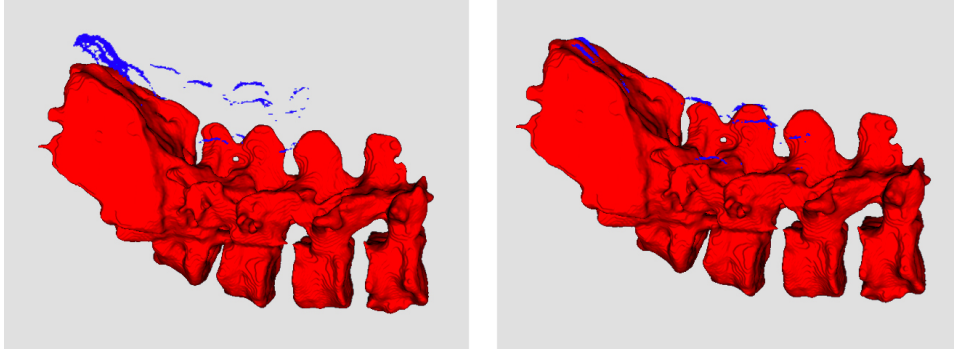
The ultrasound (blue) and MR (red) surfaces after the initial alignment (left) and after the final registration (right).
